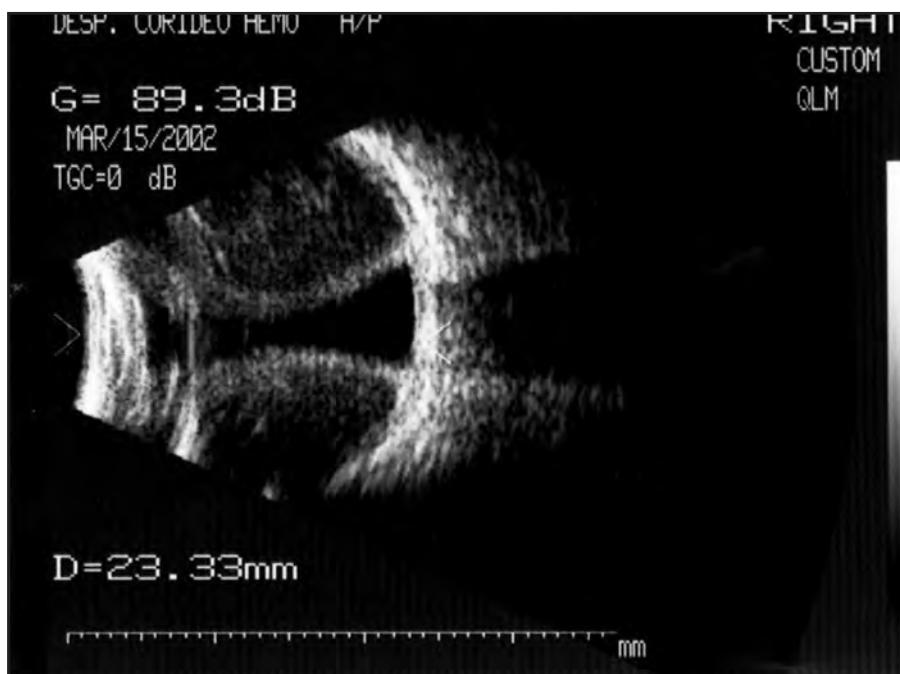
Ultrasound B-scan showing a large suprachoroidal hemorrhage without apposition, 5 days after trauma. Note that the contents of the choroidal detachment are less heterogeneous than the ones in figure 14, indicating the beginning of clot liquefaction.
